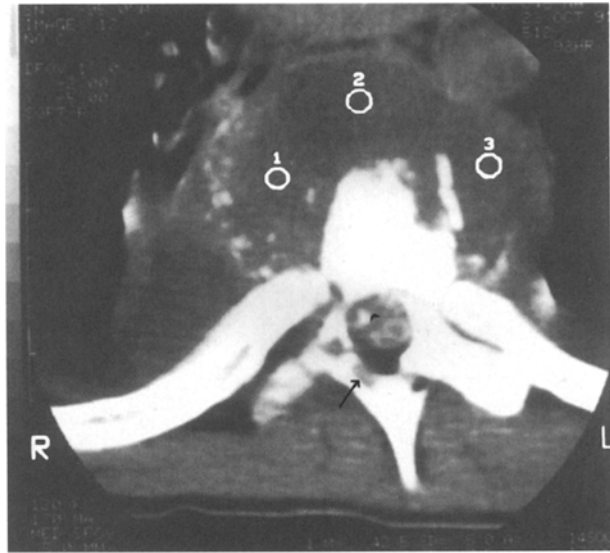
CT after myelography shows low density lymph node enlargement (1, 2, 3, rings) and associated calcification, anterior vertebral body fragmentation and an *arrow-head* indicates encroachment of the spinal canal. The destruction of the right pedicle and lamina is indicated by an *arrow*
